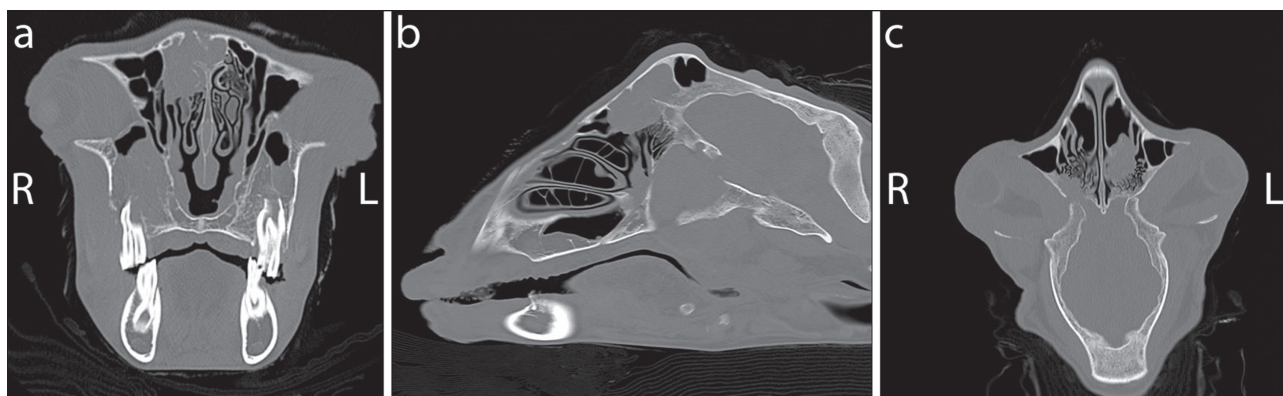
Postmortem transverse (a), sagittal (b), and dorsal (c) computed tomography bone window images of the head. A soft tissue mass is present invading the ethmoid bone and dorsal aspect of the right nasal cavity and right frontal sinus. Another soft tissue mass is present in the right maxillary sinus causing loss of the bony structures around the second, right maxillary premolar.
